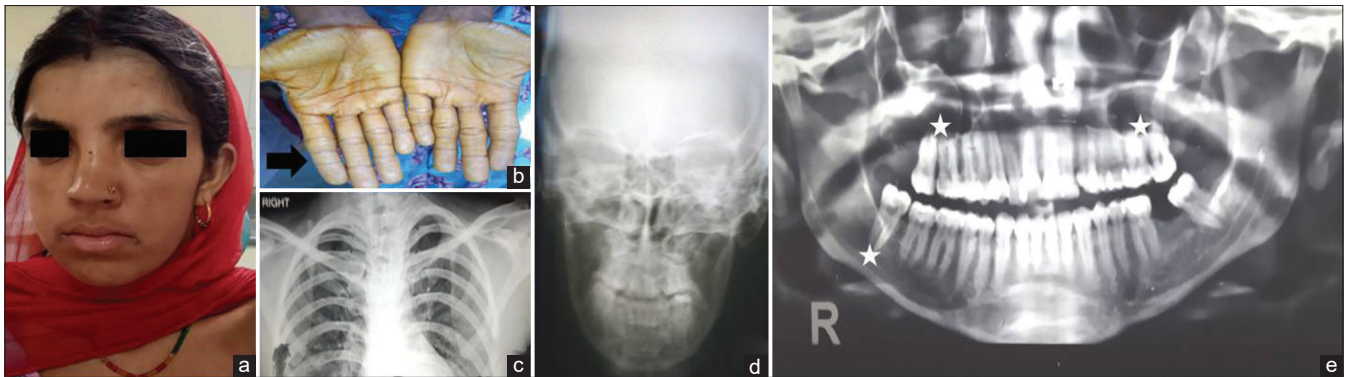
Case 4 is of a 28-year-old female showing (a) extraoral clinical photograph (b) palmar pits and elongated phalanges (c) no rib anomaly (d) PA skull X-ray (e) orthopantomogram with multiple radiolucent lesions (white asterisk)
